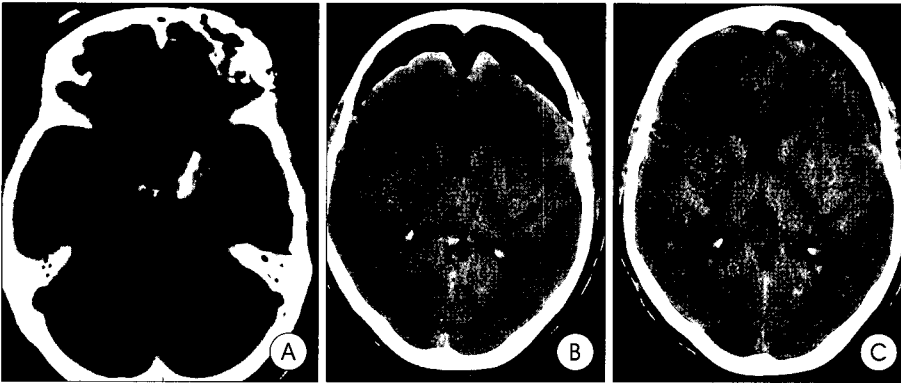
A : Immediate postoperative computed tomography(CT) scan showing no definitive tension pneumocephalus. B : Follow-up CT scan showing a subdural air density on both frontal area, known as Mountain Fuji sign. C : CT scan on third postoperative day after revision surgery showing almost disappearance of tension pneumocephalus.
